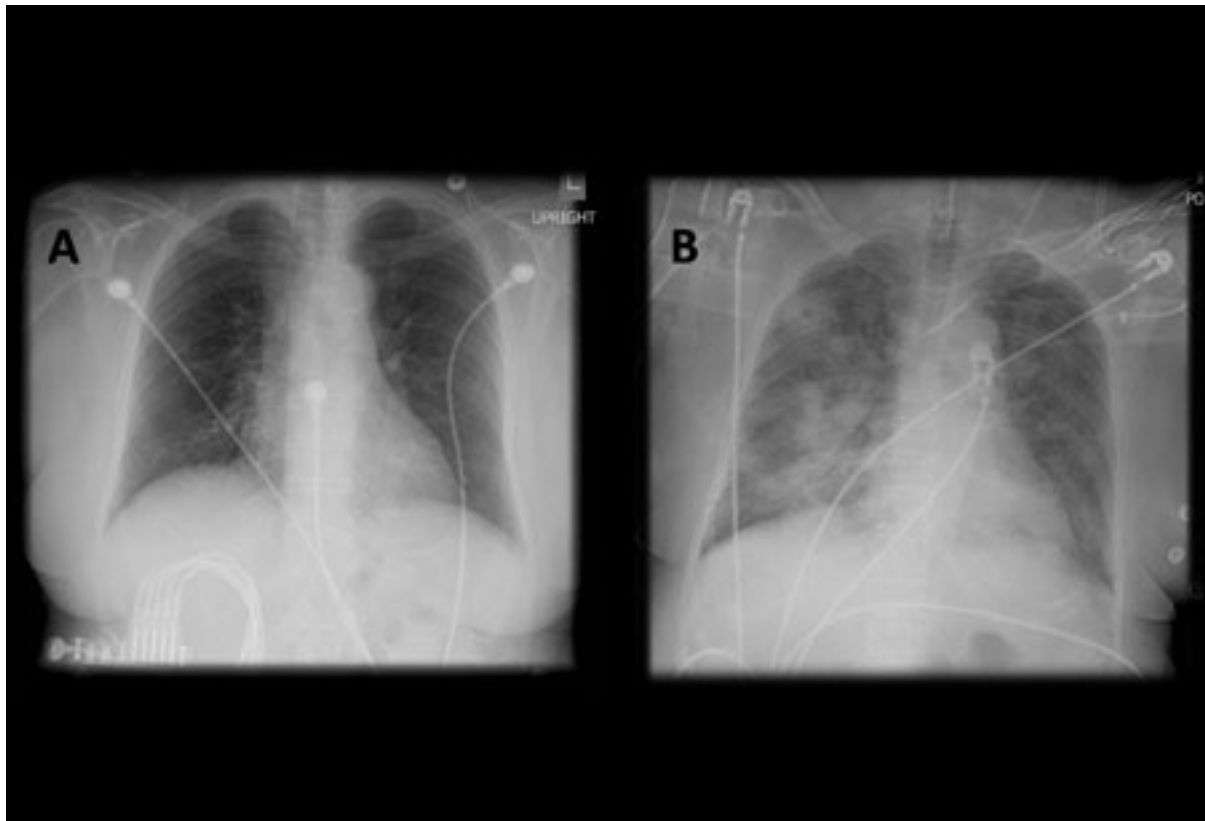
Chest x-ray showing early ill-defined opacities of the right upper lobe above the minor fissure consistent with early changes of aspiration pneumonia*
